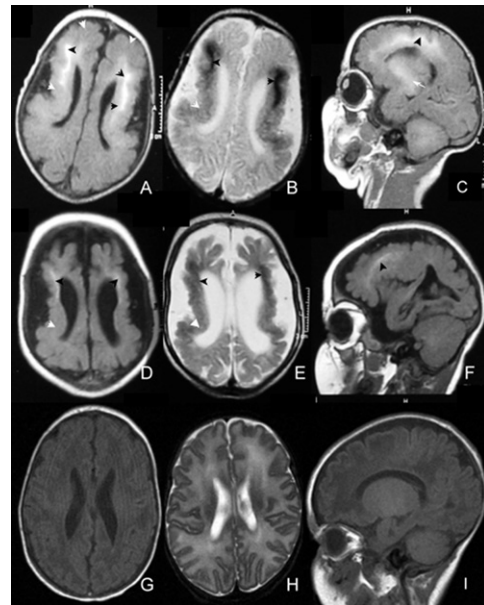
Selected MRI Images from a Single Affected Individual with BLC-PMG
